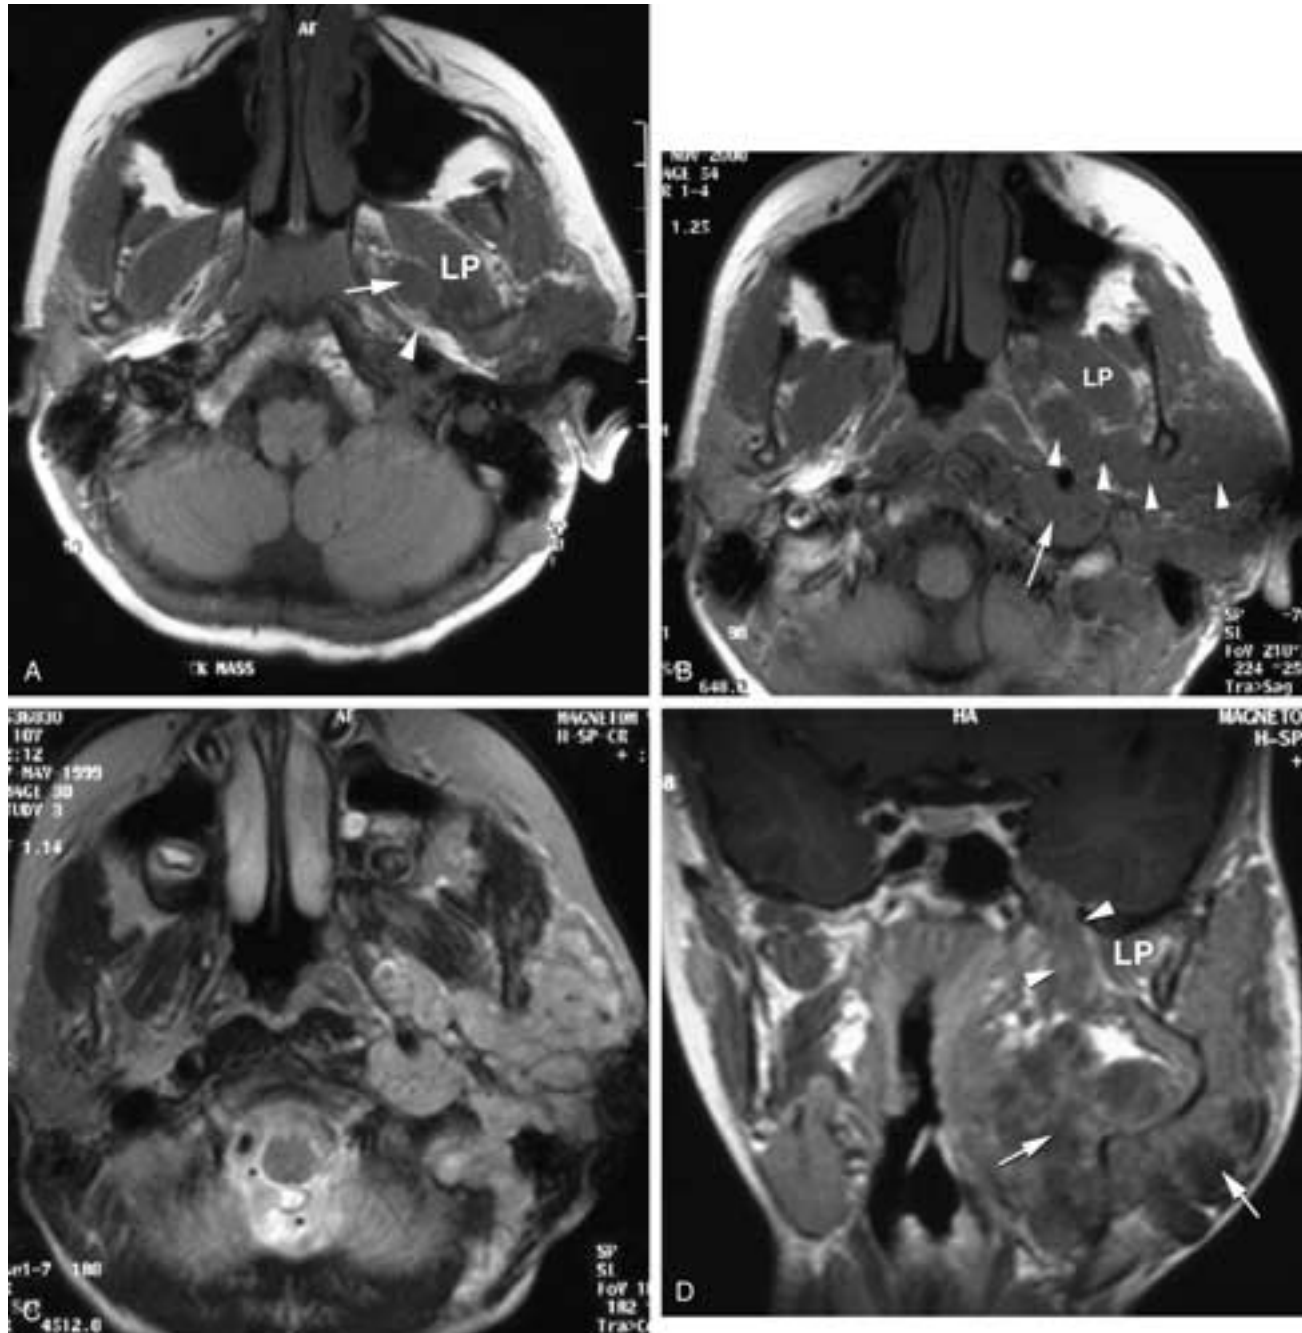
Neurofibromatosis 1 with neurofibroma extending along V_3 on the left side. Demonstration of the pathway of the auriculotemporal nerve. A, Axial T1-weighted precontrast image shows the tumor (arrow) just beneath foramen ovale along the medial margin of the lateral pterygoid muscle (LP). Note the fat (arrowhead) just beneath the skull base. B, The enlarged nerve can be followed along the course of the auriculotemporal nerve (arrowheads) extending posteriorly and laterally, just posterior to the upper mandible. LP, Lateral pterygoid muscle (arrow). A second lesion extends posterior to the carotid (arrow). C, T2-weighted image shows the relatively high signal of the lesions. D, Coronal T1-weighted postcontrast image shows the lesion extending up to and through the foramen ovale (arrowheads) just medial to the lateral pterygoid (LP). Lesions lower in the neck (arrows).
